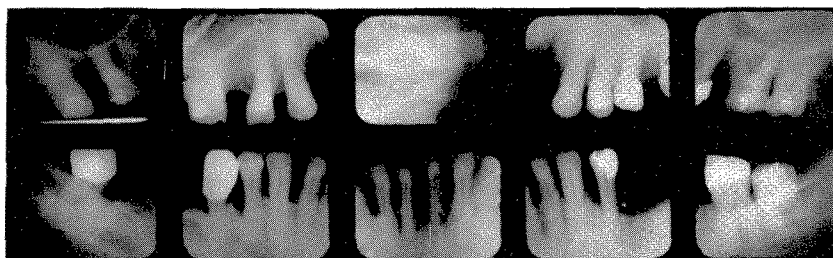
Roentgenograms taken in 1936 at the completion of the rehabilitation.
